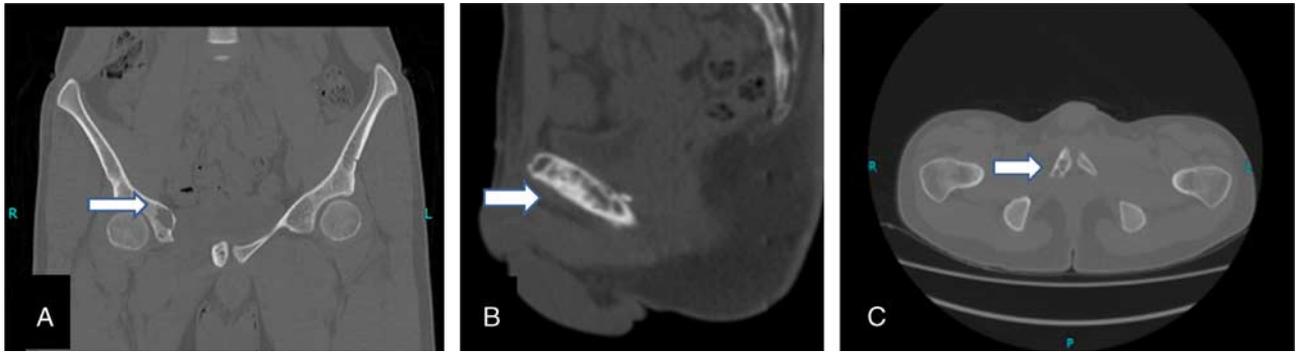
Coronal (A), sagittal (B), and axial (C) computed tomographic images of an 18-year-old boy with an aneurysmal bone cyst of the pubic bone, showing a lytic expanded mass with a thin rim of cortex peripherally but extensive destruction of cortex around (arrow).
